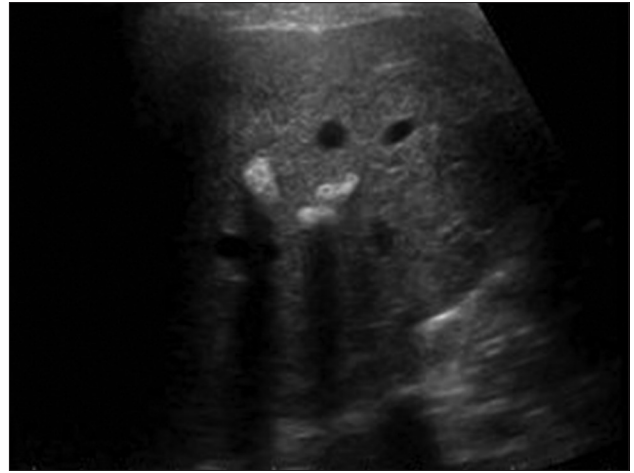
Ultrasonography showing echogenic, shadowing foci representing calculi in intra-hepatic biliary ducts
